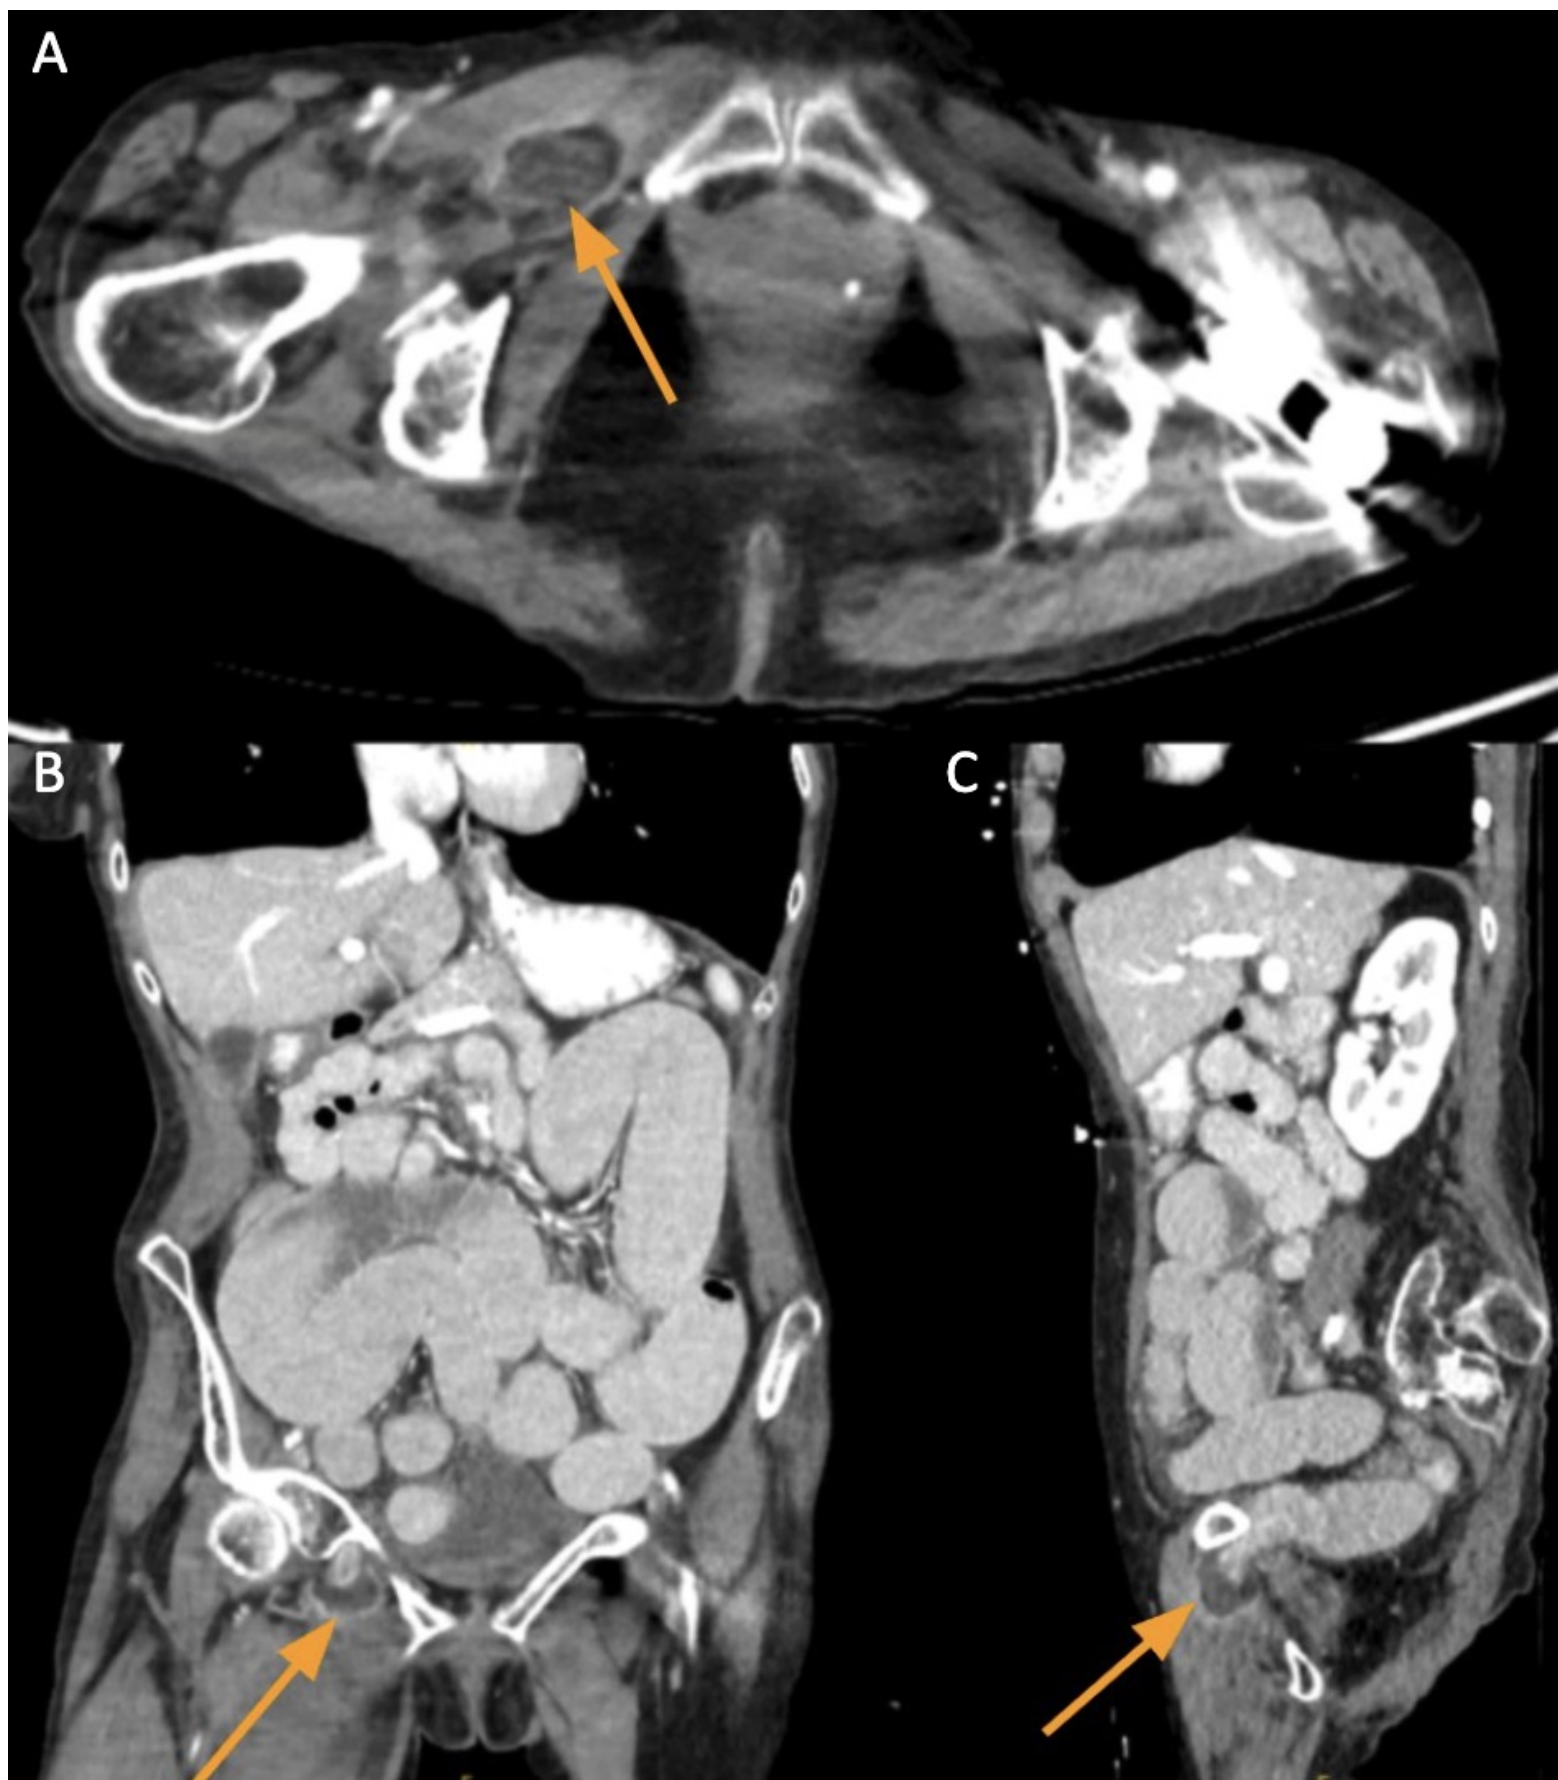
Contrast-enhanced computed tomography (CETC) axial(A), coronal(B), and sagittal(C) sections. Orange arrows showing right-sided obturator hernia with small bowel herniating through the right obturator canal.
